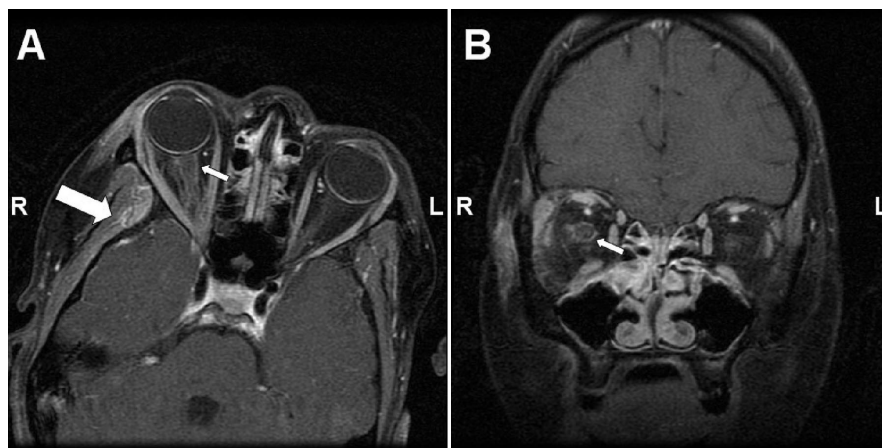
weighted MR images of the orbits with gadolinium in axial (A) and coronal (B) views. There was abnormal enhancement in the right (R) orbit encasing the optic nerve (small arrow), the periorbital fat, and the right infratemporal musculature (large arrow). There was no imaging abnormality on the left (L).
